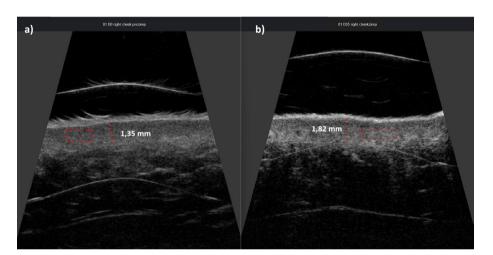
Participant 1. Ultrasound imaging with DermaMed device, 48 MHz probe: a) baseline image prior to treatment initiation; b) posteatment image at Visit 6 after three injection sessions. Source: Author's own archive
